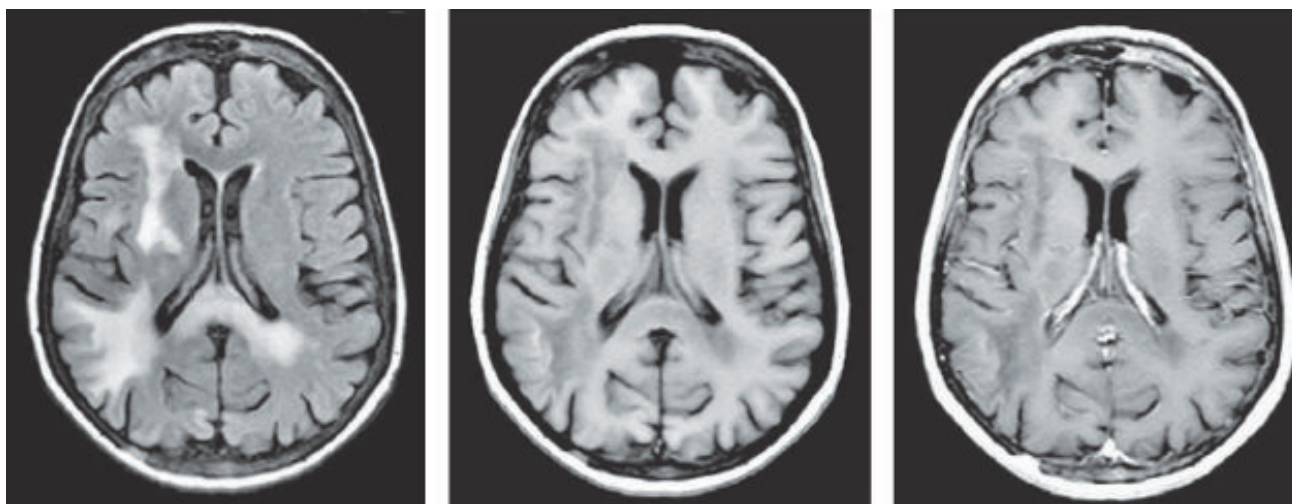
A MRI scan FLAIR, T1WI and T1WI+C
